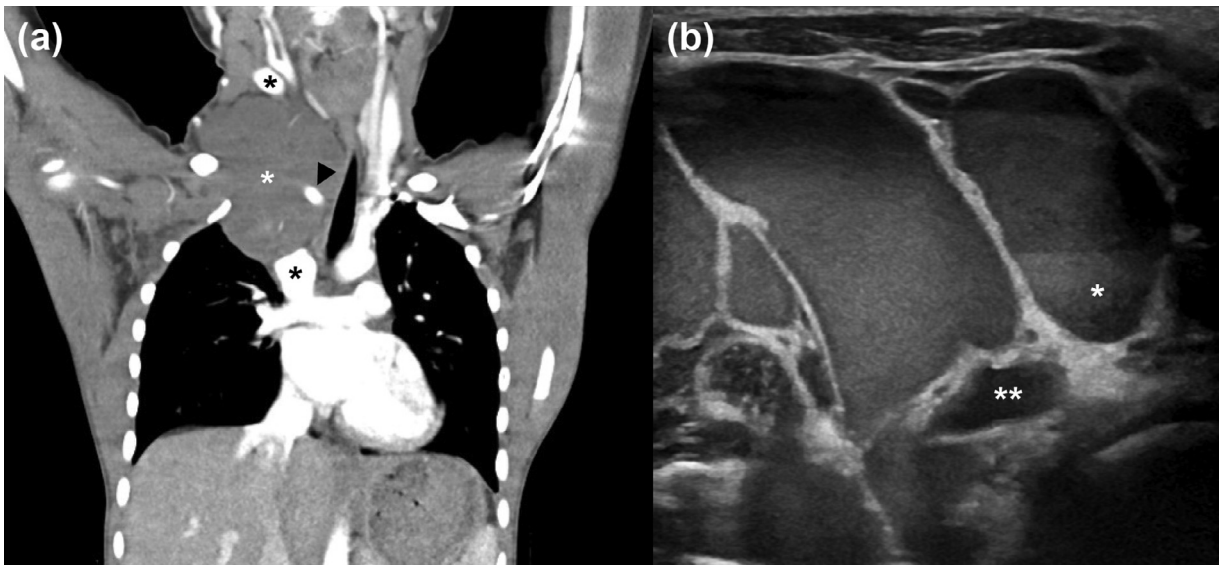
Findings of the (A) initial computed tomography (CT) and (B) ultrasound, suggesting lymphatic-venous malformation with internal hemorrhage. (A) On the CT, a 6.5 × 3.5 × 7.3-cm sized, well-defined, multi-loculated cystic, low-density mass (white asterisk) spans from the neck to the mediastinum. The mass interrupts the junction between the right internal jugular vein and superior vena cava (black asterisks), encases the brachiocephalic trunk (arrowhead), and compresses the trachea. (B) The sonogram shows the multi-loculated cyst with fluid-fluid level, which was considered an internal hemorrhage (asterisk). The internal jugular vein remains patent (double asterisks) despite the interruption between the two large veins on CT.
